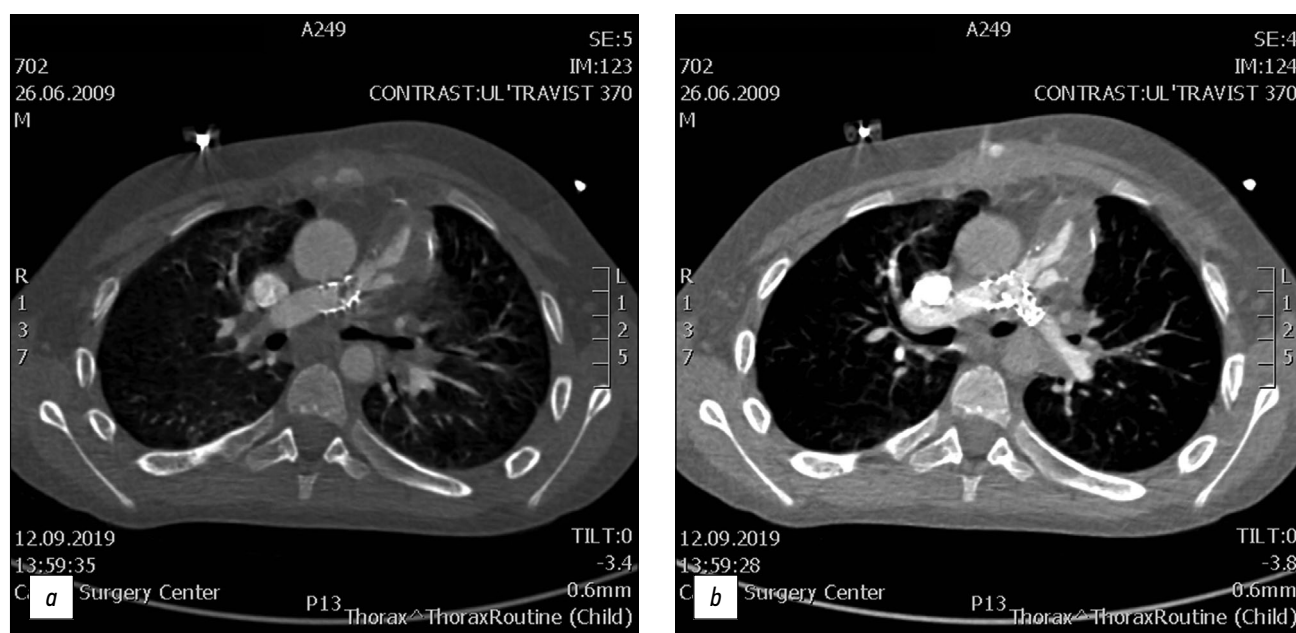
CT of valve-containing conduit Contegra No. 16 and bilateral stents Palmaz Genesis XD 19-10.
